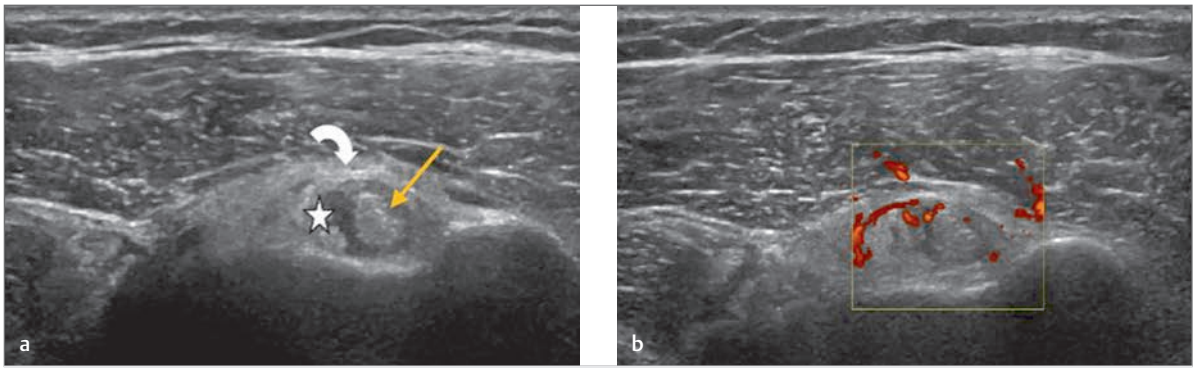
(a, b) Transverse image of the bicipital groove. The image demonstrates a tendinopathic long head of biceps (yellow arrow). In addition, there is synovial thickening within the bicipital sheath (white star) with bowing of the transverse ligament (white curved arrow). The right hand image demonstrates the associated Doppler signal within the bicipital sheath indicating tenosynovitis.
